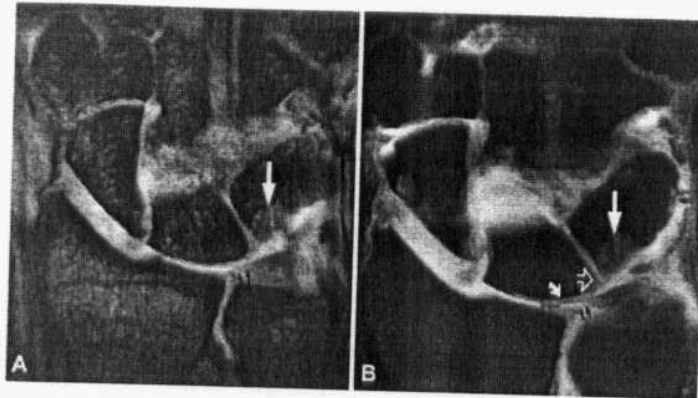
Class IIE lesion with ulnocarpal arthritis demonstrates a central TFC perforation (small straight arrows), lunate (curved arrow) and triquetral chondromalacia, lunotriquetral ligament tear (open arrow), and triquetral subchondral erosion (long straight arrow) (A: T2*-weighted coronal image; B: fat-suppressed T1-weighted coronal arthrographic image)(Quoted from Stoller and Brody, 1997).
